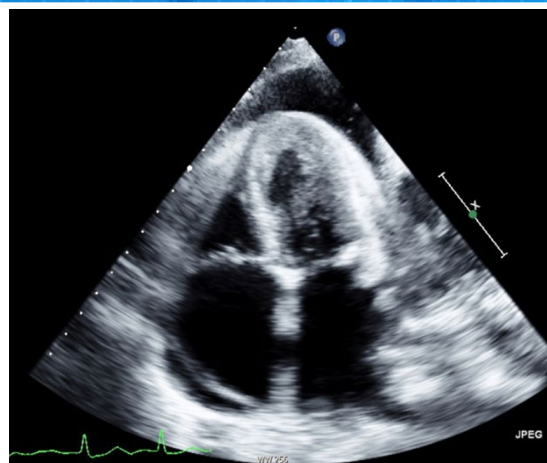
Transthoracic echocardiography showed fluid in the pericardium at the apex of the heart and right ventricular collapse.
